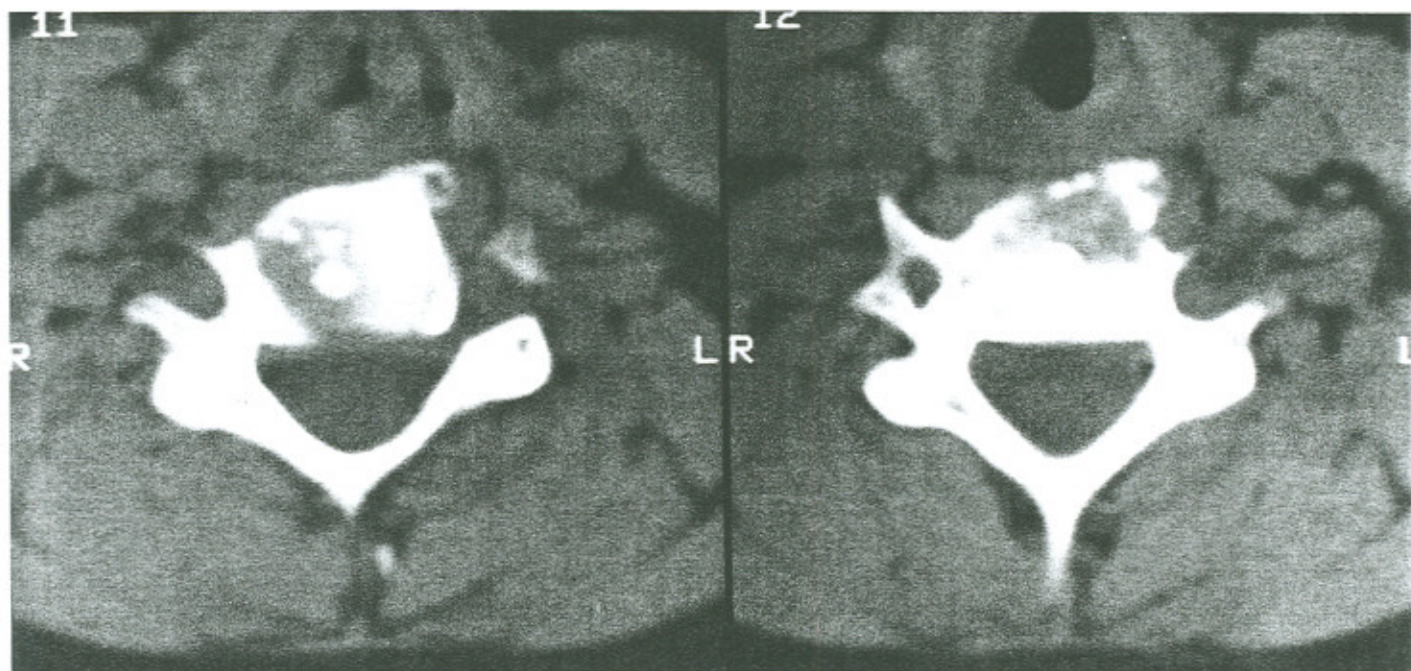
CT scan of the mid and lower cervical spine shows the intervertebral disc calcification extending anteriorly at the C5–C6 level. The spondylophyte at the anteroinferior aspect of the vertebral body of C5 is seen extending more towards the left than the right. No abnormality is seen within the spinal canal.
